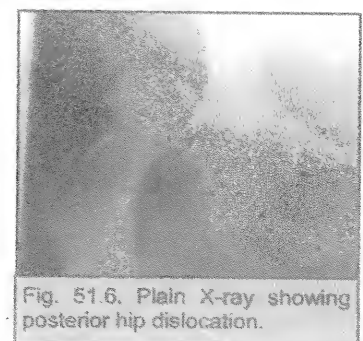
Plain X-ray showing posterior hip dislocation.
